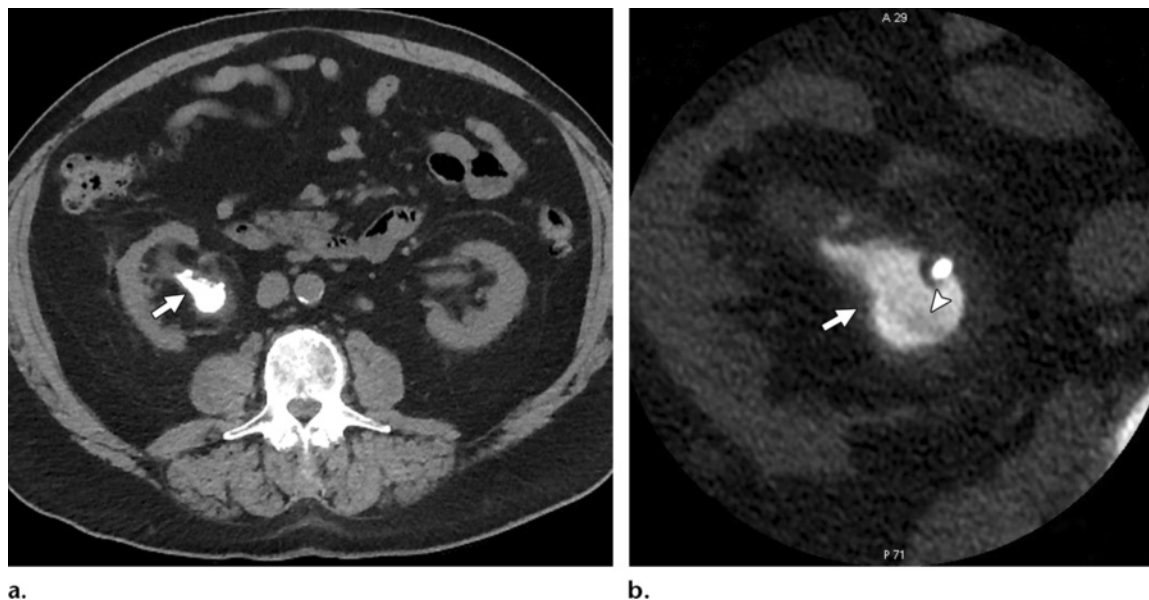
Staghorn calculus in a 63-year-old man. (a) Axial CT scan (abdominal window settings [400/30]) shows a staghorn calculus (arrow). (b) High-resolution CT scan (bone window settings [1120/300]) demonstrates internal inhomogeneities in the form of low-attenuation areas (arrowhead) within the calculus (arrow).
